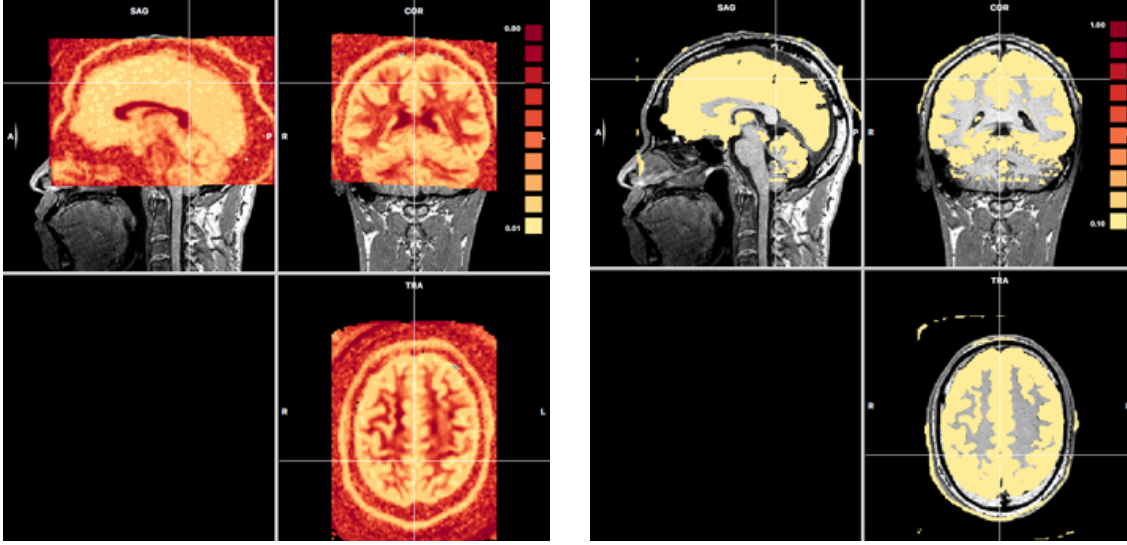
FA (on the left) and MD (on the right) maps registered on the patient anatomical MRI.
